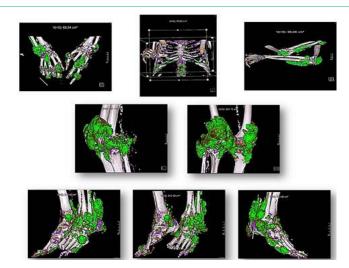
Dual energy-CT of both hands (a), chest (b), elbows (c), knees (d) and feets (e) show MSU deposits (green colour) revealing a high score of 1014, 4cm^3 tophi volume = 2316, 5mg weight (C5H₂N₂O₃Na; molecular weight, 190.09).
